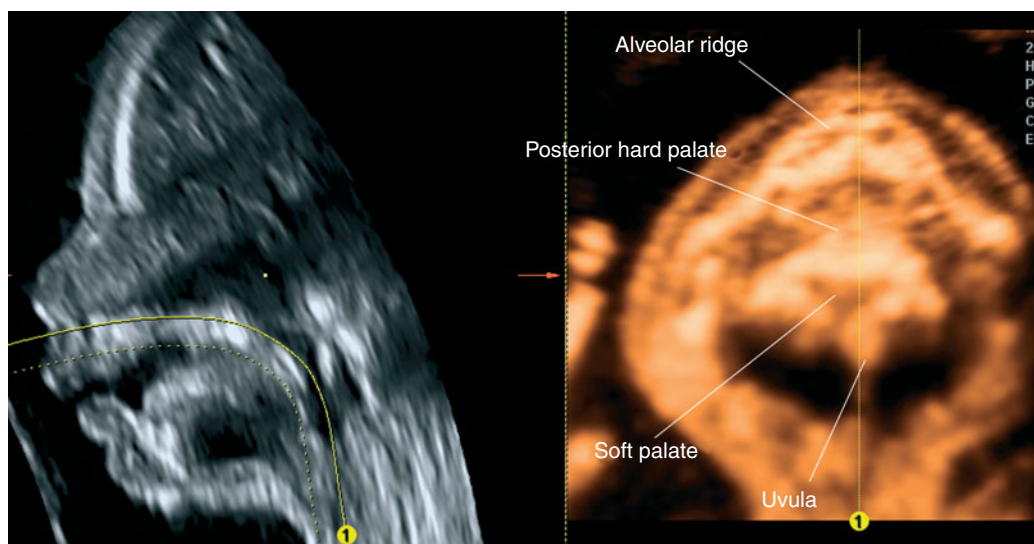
3D sonography of the fetal palate. The mouth of the fetus is slightly open, and some fluid is found between the palate and the tongue. By using a curvilinear cut, it is possible to demonstrate both the hard and the soft palate, including the uvula. (Reproduced, with permission, from Pilu G. *Atlas of Obstetric Ultrasound*, The Global Library of Women's Medicine, www.glowm.com.)
